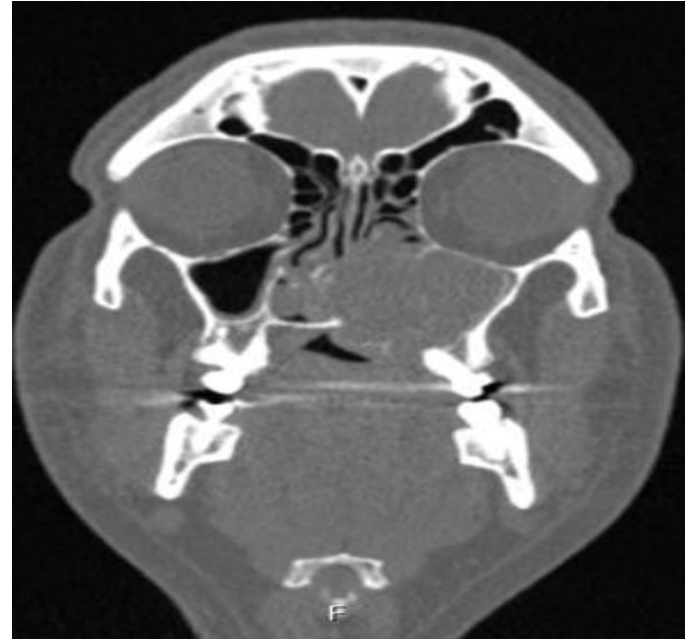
The appearance of the lesion on coronal CT.
